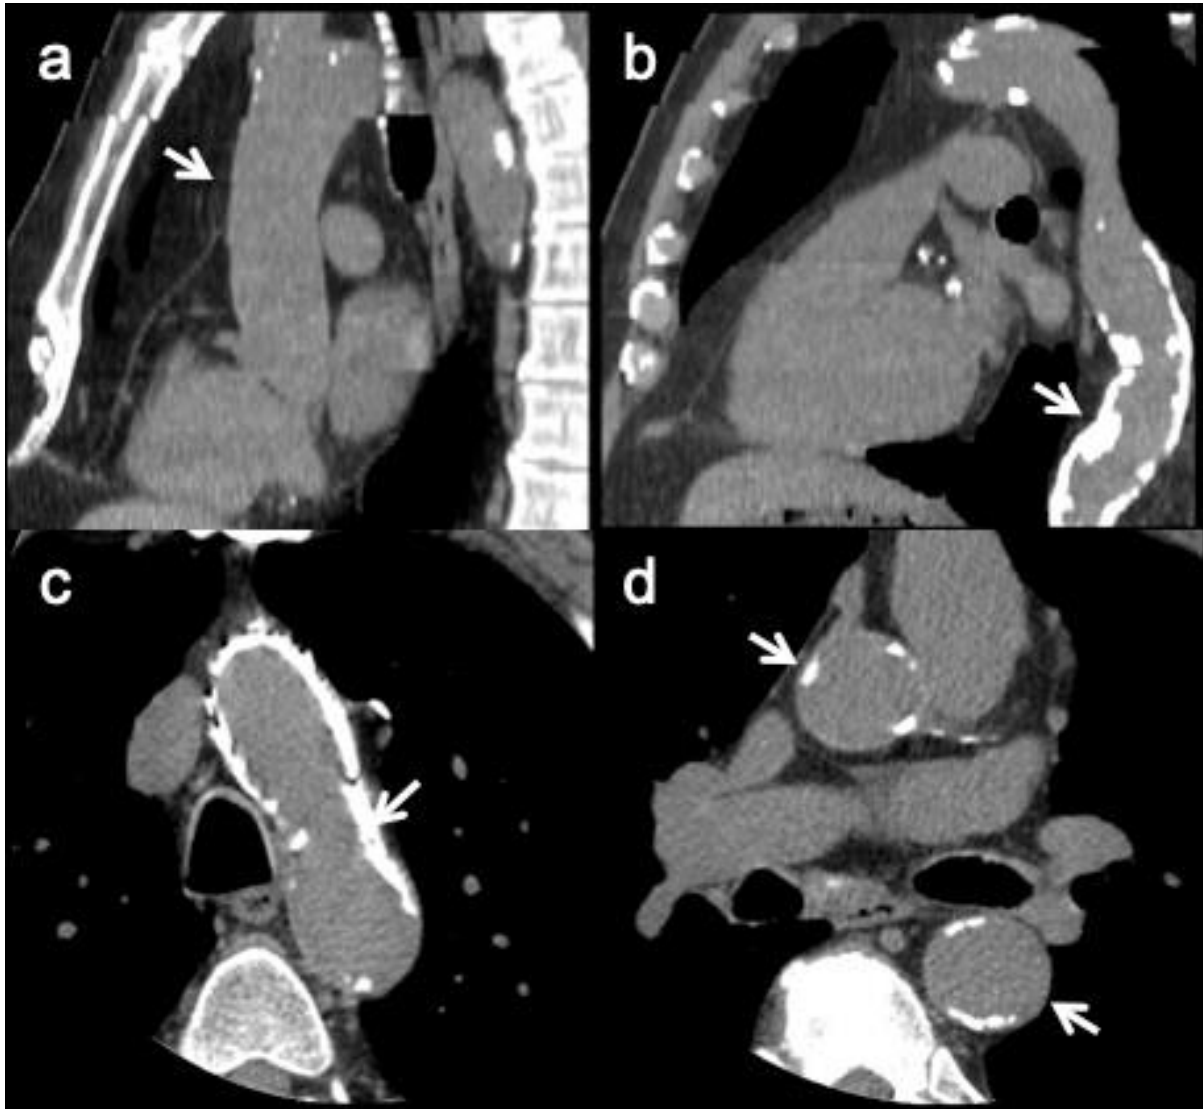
Heterogeneous distribution of calcium along the aorta. a, b CT reconstructions in the parasagittal plane. In this case, ascending aorta had no calcium (arrow in image 1a), whereas in the arch and descending portions (arrow in b) there were circumferential plaques covering almost all aortic wall. C, d CT reconstructions in the axial plane. The most calcium concentration was in the aortic arch (arrow in c), while in ascending (superior arrow in d) and descending (inferior arrow in d) segments calcium were coarse, but sparse.
